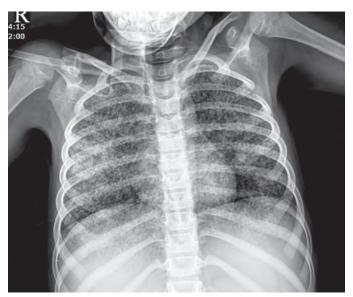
Chest radiograph: Multiple tiny nodular infiltrates distributed diffusely in bilateral lung fields, suggestive of miliary tuberculosis
